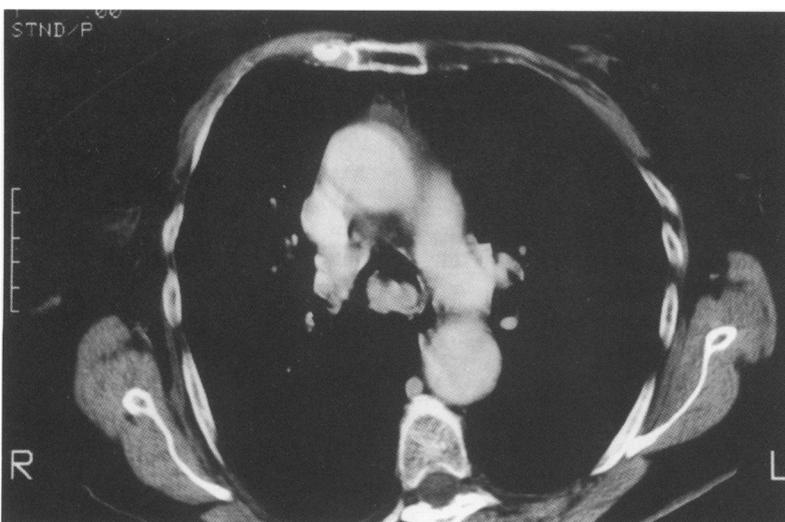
Thoracic computed tomographic scan (mediastinal window) showing tumour spread into the subcarinal space.
